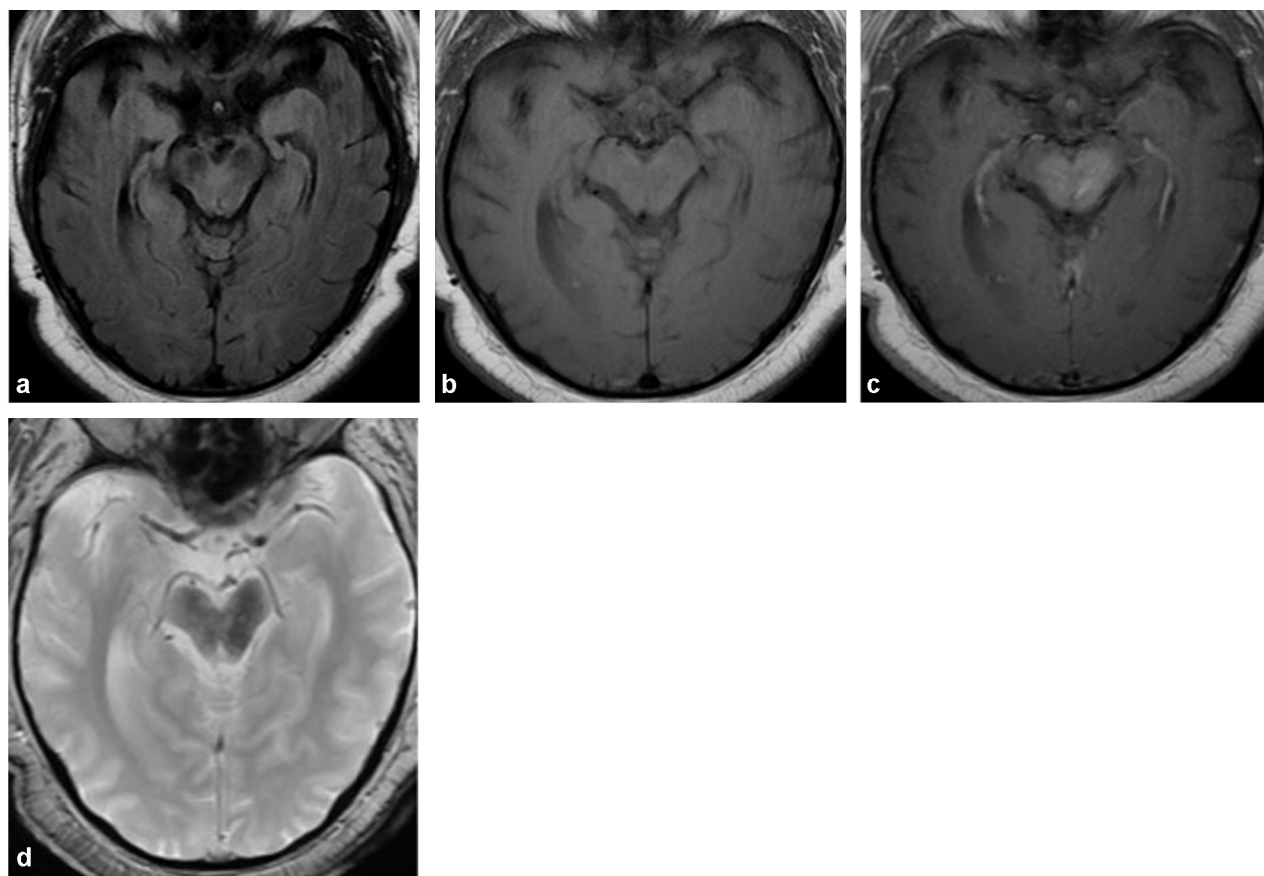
Capillary telangiectasia. FLAIR axial (a), T1 (b), T1 after injection (c), T2* (d). Mesencephalic lesion in FLAIR and T1 isosignal, T2* hyposignal, and enhanced after injection with a striped appearance linked to multiple dilated capillaries. Absence of perilesional oedema and mass effect.
